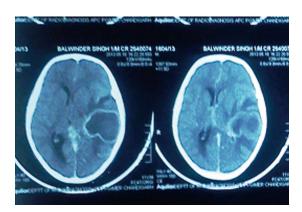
Contrast-enhanced computed tomography of the patient showing left temporoparietal abscess.
